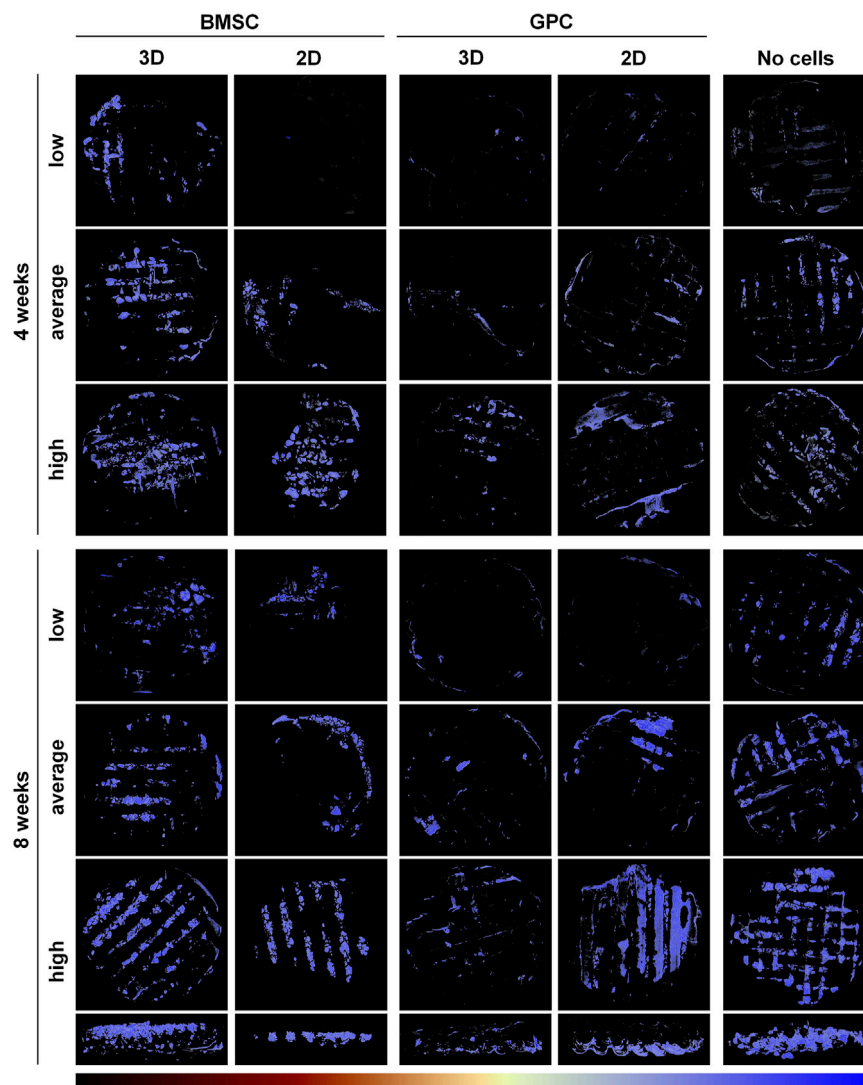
μ CT analysis of ectopic mineralization. Representative reconstructed images showing “low, average and high” degrees of mineralization in BMSC, GPC and control constructs (no cells) after 4 and 8 weeks; the bottom row shows cross-sectional views of the corresponding “high” constructs at 8 weeks. The color bar indicates relative mineral density from minimum (black) to maximum (blue).
